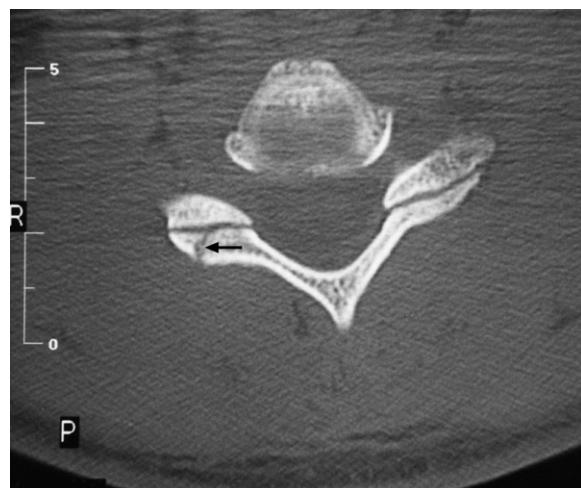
Cervical spine CT axial image. Note the fracture (black arrow) extending through the right inferior articular process and facet of C5 on the right.
